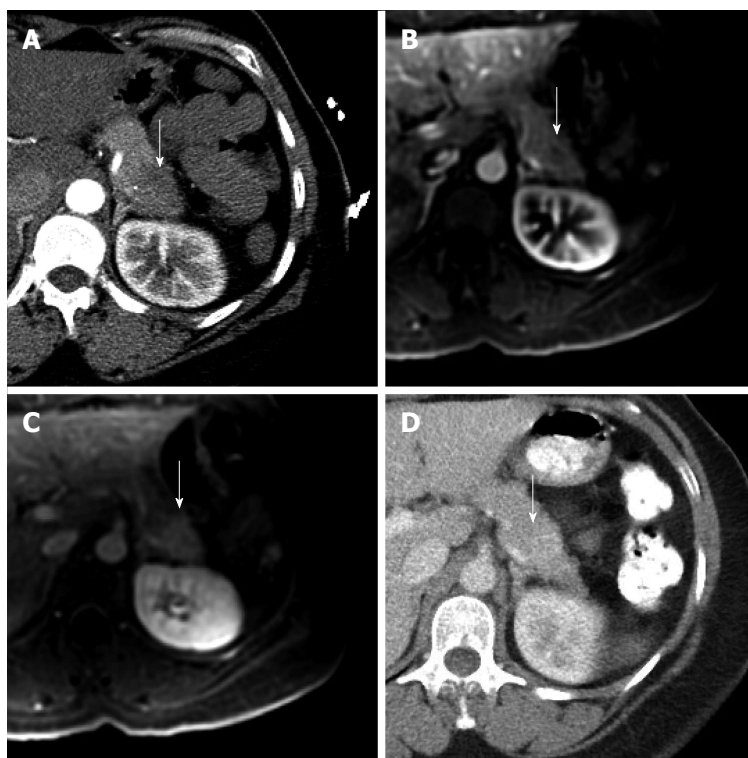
Delayed enhancement on computed tomography and magnetic resonance imaging in autoimmune pancreatitis. A, B, C: Focal autoimmune pancreatitis in the pancreatic tail (white arrow) with delayed early arterial enhancement on arterial phase computed tomography (CT) (A) and magnetic resonance (B, fat-saturated T1-weighted image, 30 s post-injection), with subsequent delayed enhancement (C, fat-saturated T1-weighted image, 180 s post-injection); D: Follow-up CT after corticosteroid therapy demonstrating resolution of prior enhancement abnormality (white arrow).
